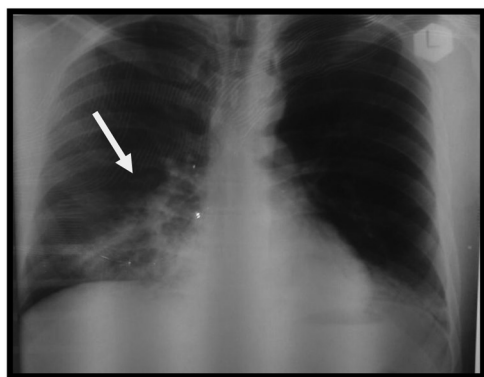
Chest X-ray on admission (Areas marked with arrows show basal and perihilar infiltrates with low transparency).
